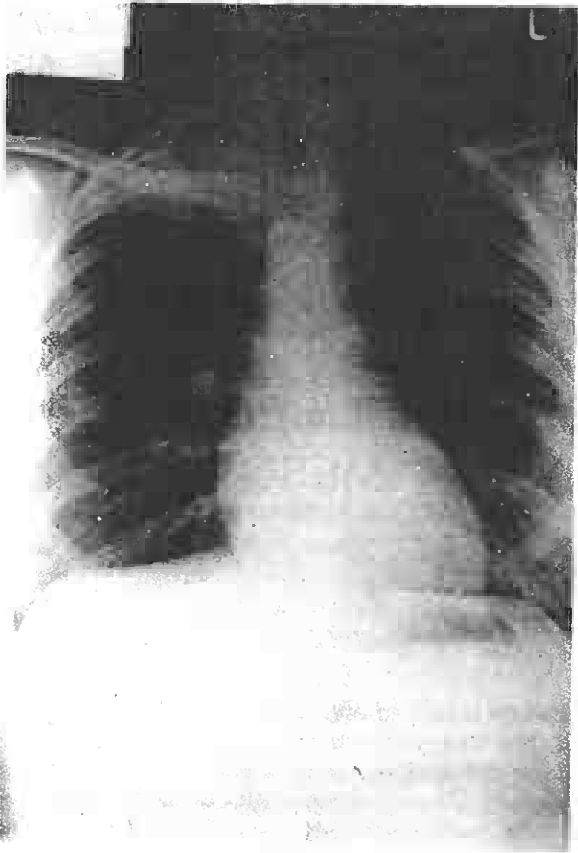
Chest x-ray: PA view showing opacity at apex of right lung
